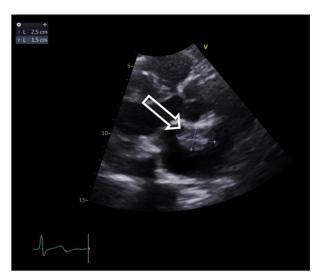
Transthoracic echocardiogram showing 2.5×1.5 cm fixed mass in the fossa ovalis, consistent with cardiac myxoma.
